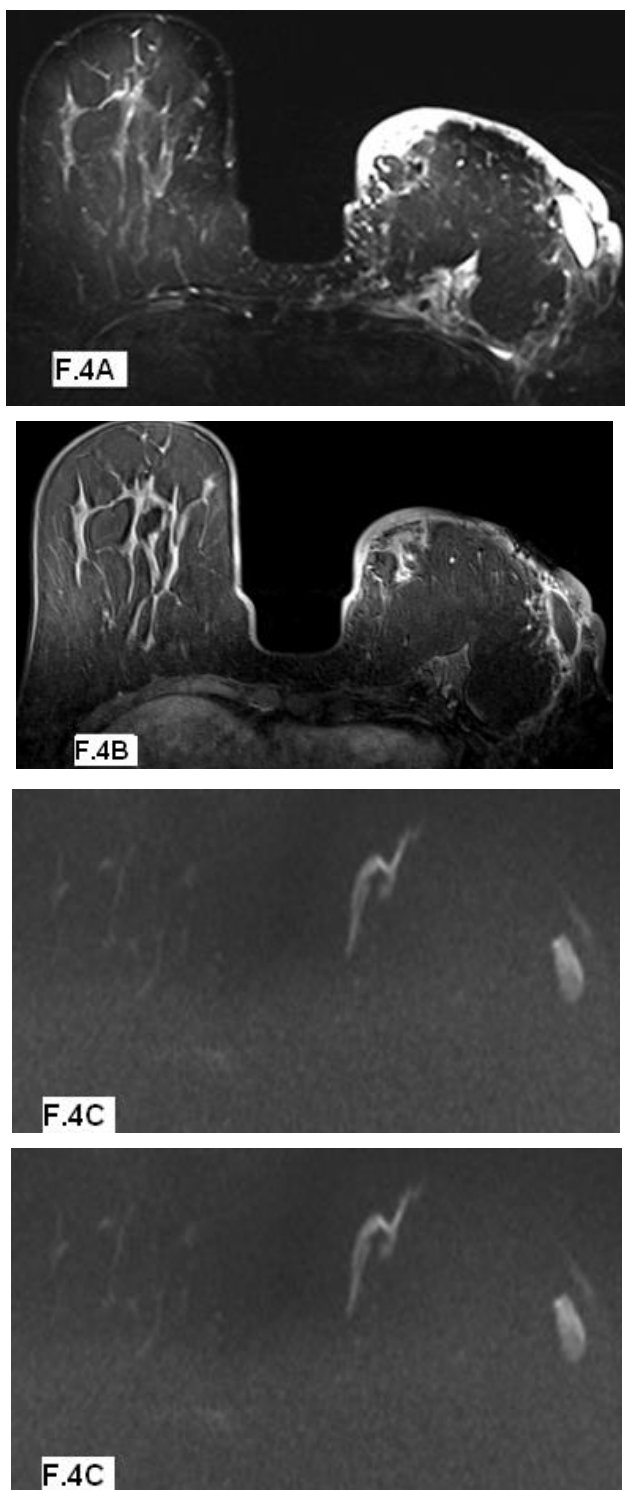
Post-operative seroma. 36 year-old female submitted to left quadrantectomy 10 months ago for ductal carcinoma. (A) Axial T2 FS & (B) post-contrast GRE (VIBE) demonstrate left breast fluid collection with surrounding granulation tissue and marked skin edema. (C) DWI with $b= 800$ shows slightly hyperintense lesion (due to T2 shine through effect). (D) The ADC map shows hyperintense lesion with ADC value of about $2.46 \times 10^{-3} \text{ mm}^2/\text{s}$
